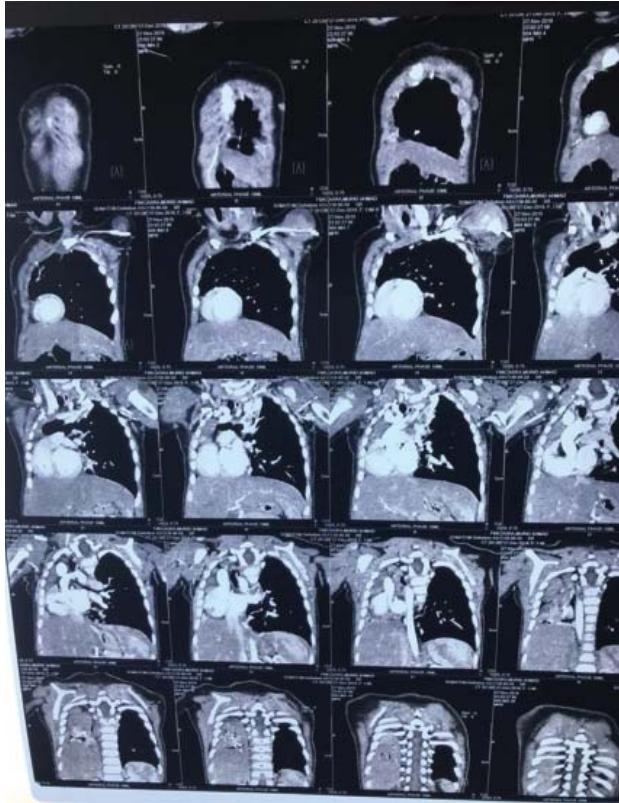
CT chest showing hypoplastic right lung and dextroverted heart
